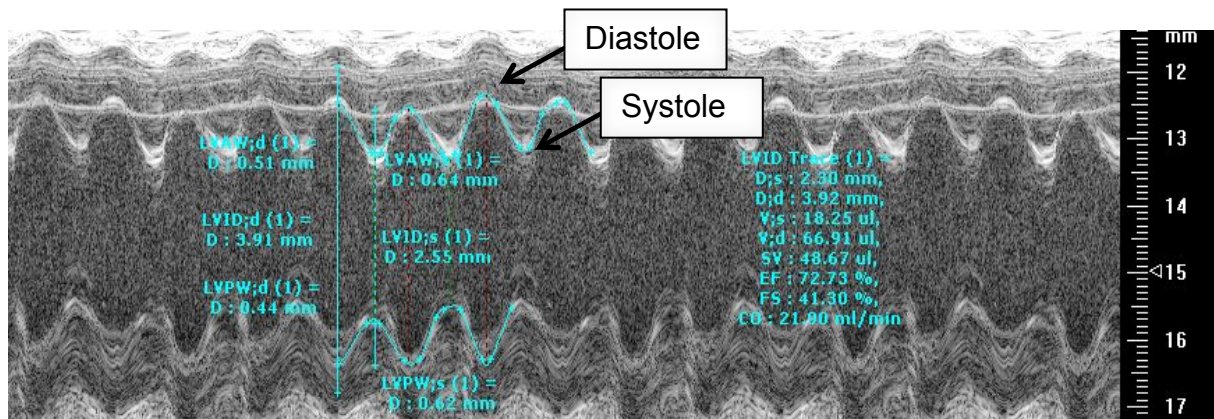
Representative M-Mode Echocardiography Image
